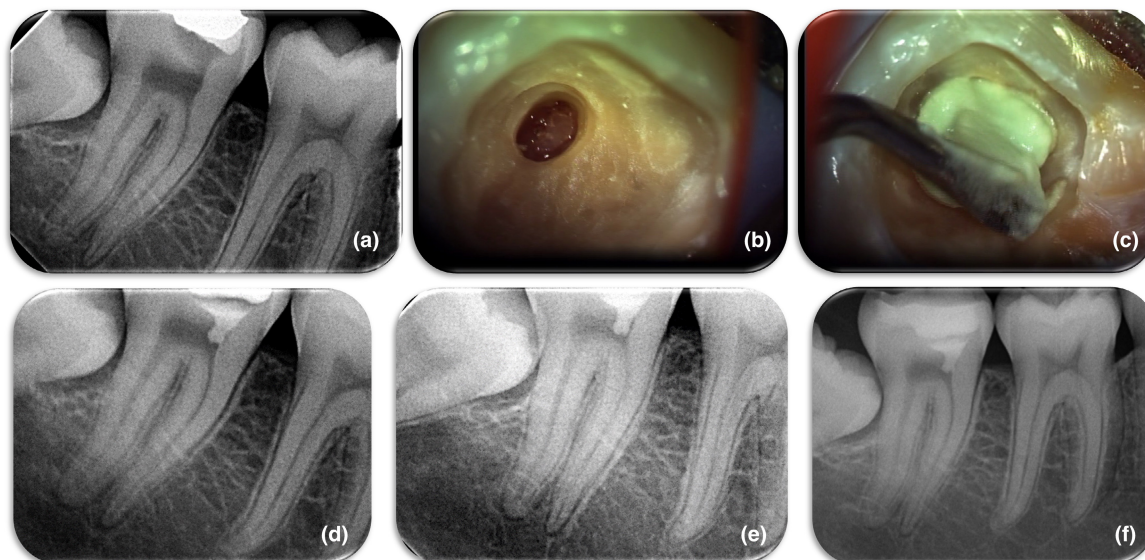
(a) Initial radiograph of a mature second mandibular molar of a 17-year-old patient. Note the extremely deep caries under the permanent restoration and the widening of periodontal ligament space, (b) complete caries removal and first communication with the pulp chamber. Note the pulp stone inside the mass of the tissue, the stone has to be removed, (c) placement of MTA Angelus as pulp capping material, (d) postoperative radiograph of the case, (e) 6-month recall radiograph, (f) 24-month recall radiograph, note that the widening of periodontal ligament space has been resolved.
